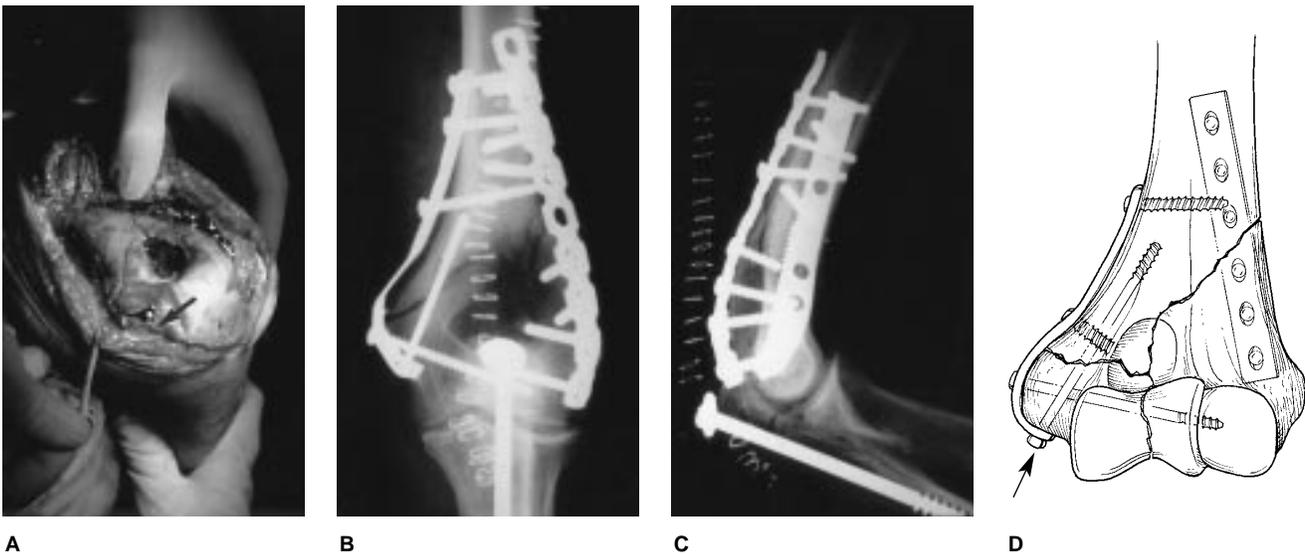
A, Pathologic type A fracture with a low medial-column component. A flattened one-third tubular plate contoured to go around the medial epicondyle was used for fixation. Instrumentation imposed on the cubital tunnel (arrow) and necessitated transposition of the ulnar nerve. Anteroposterior (B) and lateral (C) radiographs depict arrangement of the plates at right angles to each other. D, Lag-screw fixation through a medial-column plate (arrow) often encroaches on the cubital tunnel and necessitates an ulnar-nerve transposition.
